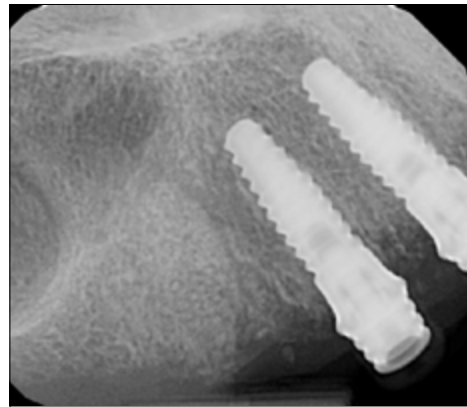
Periapical radiograph showing the healed site.
